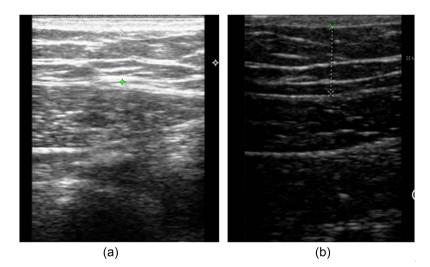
Ultrasonography—Right side: Pretreatment (a) and Post-treatment (b).
